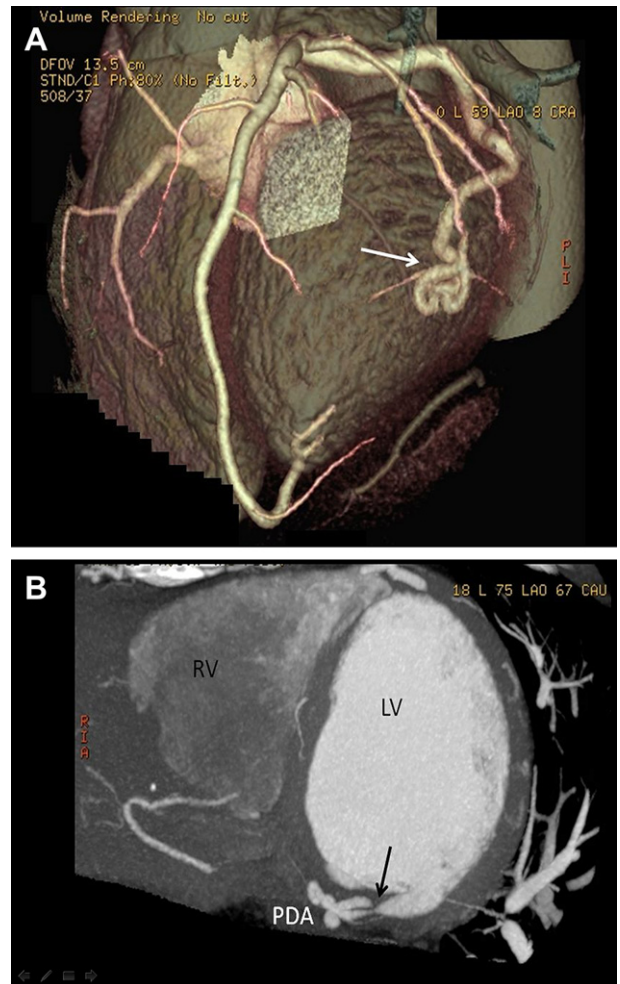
(A) Volume rendering cardiac imaging reveals a dominant left coronary system. The PDA is dilated and tortuous (arrow), and originates from the left circumflex artery. (B) Reformatted two-dimensional cardiac computed tomography clearly defines the connection (arrow) between the LV and PDA. CAU = caudal; CRA = cranial; DFOV = dual field of view; LAO = left anterior oblique; LV = left ventricle; PDA = posterior descending artery; RV = right ventricle; STND = standard.
